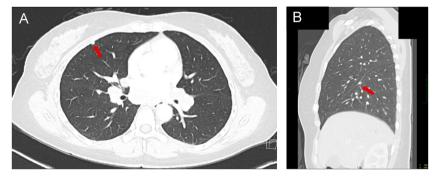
(A) February 3, 2020 CT Thorax: Subpleural nodule (arrow), axial image. (B) February 3, 2020 CT Thorax: Right oblique fissure nodule (arrow), sagittal image.
